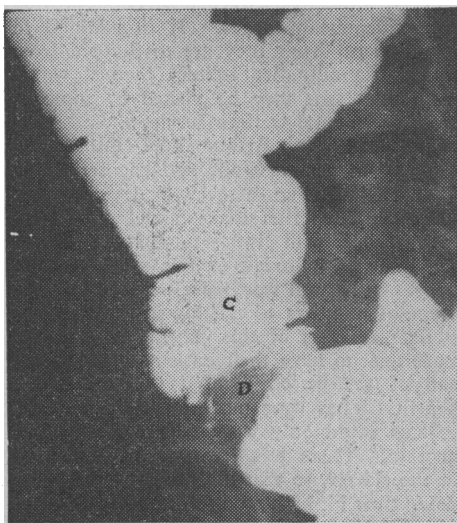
Radiograph showing the caecum (C) with a persistent filling defect (D) at its base.
